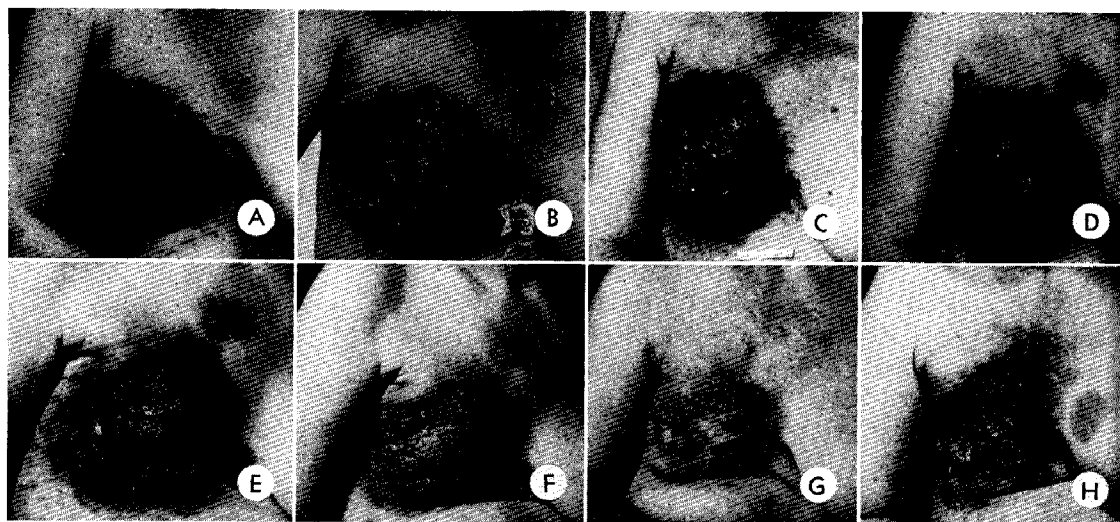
This pictorial sequence portrays the increased mammary cancer growth after ultrasonic irradiation of the pituitary gland in Patient 5. The continuum shows also the striking response to adrenal and ovarian ablation. (A) Three weeks and (B) 1 week pre-ultrasonic irradiation of pituitary, (C) $4\frac{1}{2}$ weeks post irradiation, (D) 12 weeks post irradiation and 2 days pre-adreno-oophorectomy, (E), (F), (G) and (H) $2\frac{1}{2}$ weeks, 5 weeks, 8 months, and 12 months post-adreno-oophorectomy.
